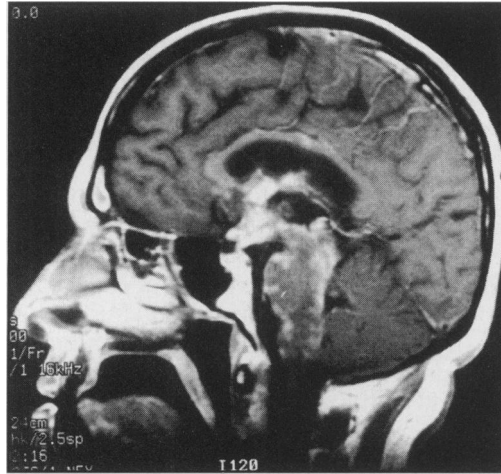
Sagittal T1-weighted MR image with gadolinium enhancement
